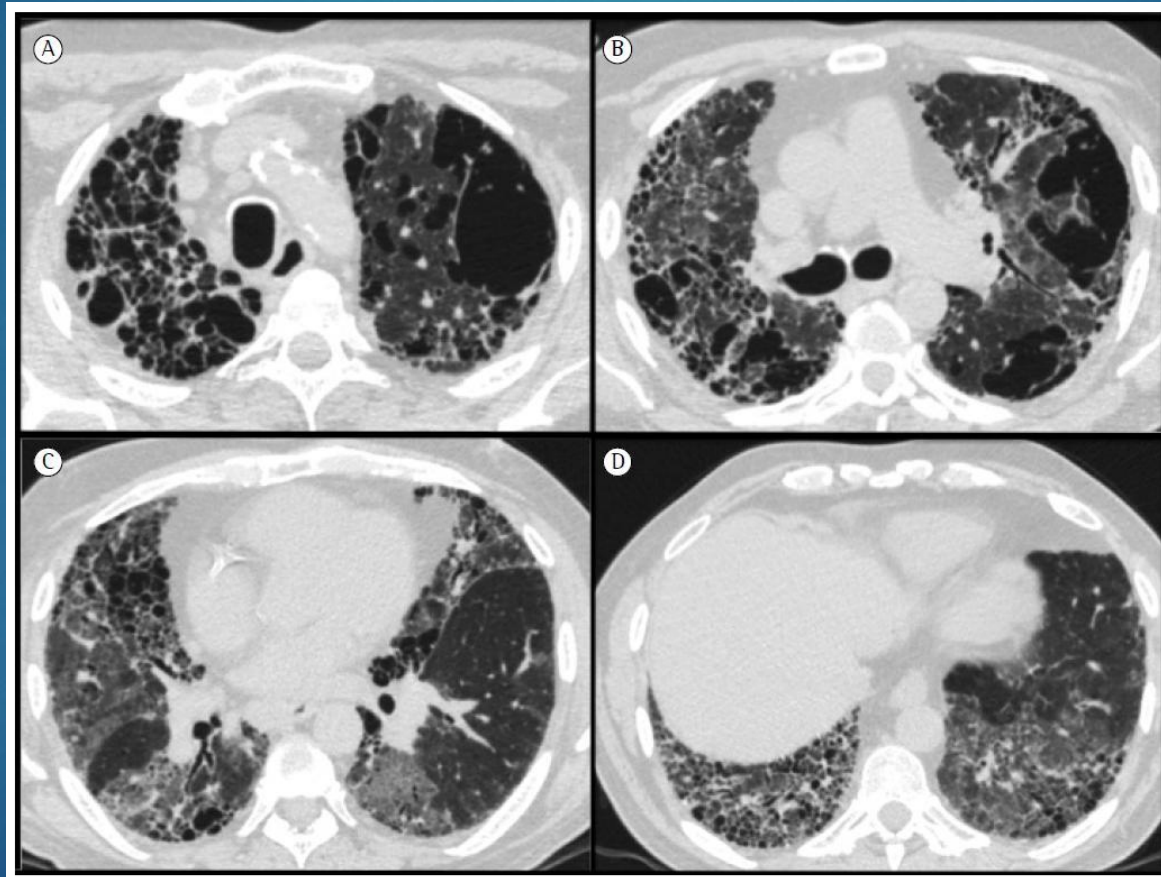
CT scan of the chest of a 70-year-old male patient with combined pulmonary fibrosis and emphysema and acute exacerbation of interstitial disease. Note predominantly paraseptal emphysema in the lung apices, with architectural destruction of the lung parenchyma (A and B). Extensive areas of ground-glass opacity and honeycombing can be seen in the lower lobes (C and D)
